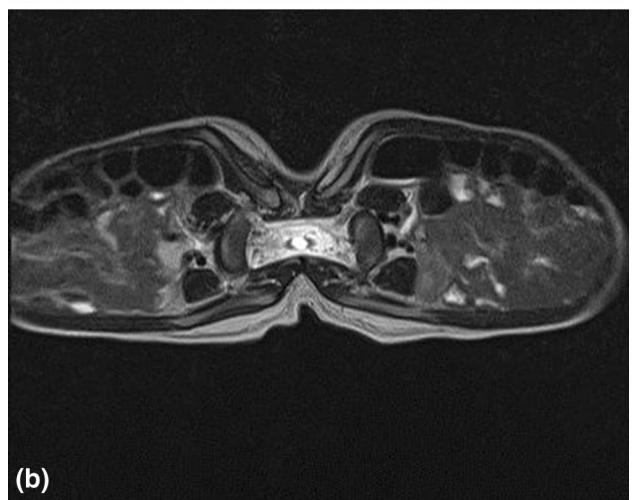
MRI of pygopagus conjoined twins
